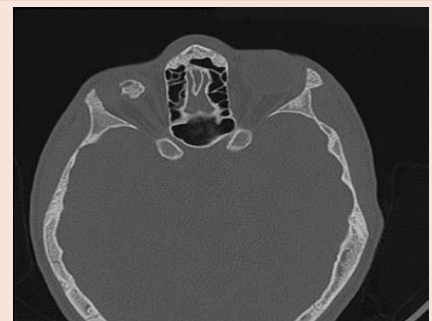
CT-axial imagine shows right eyeball reduced in size with numerous calcifications.
